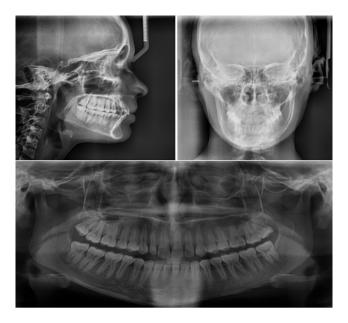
Post-treatment lateral and Posteroanterior cephalograms, Panoramic radiographs
